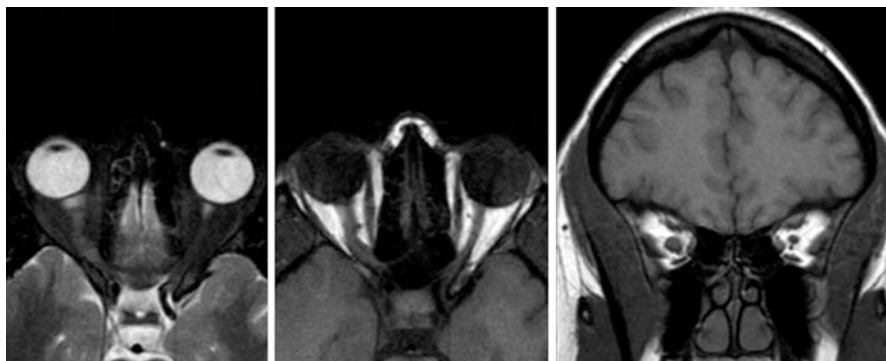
MRI scan of orbits showing enlargement of the optic nerve – sheath complex on the right side
